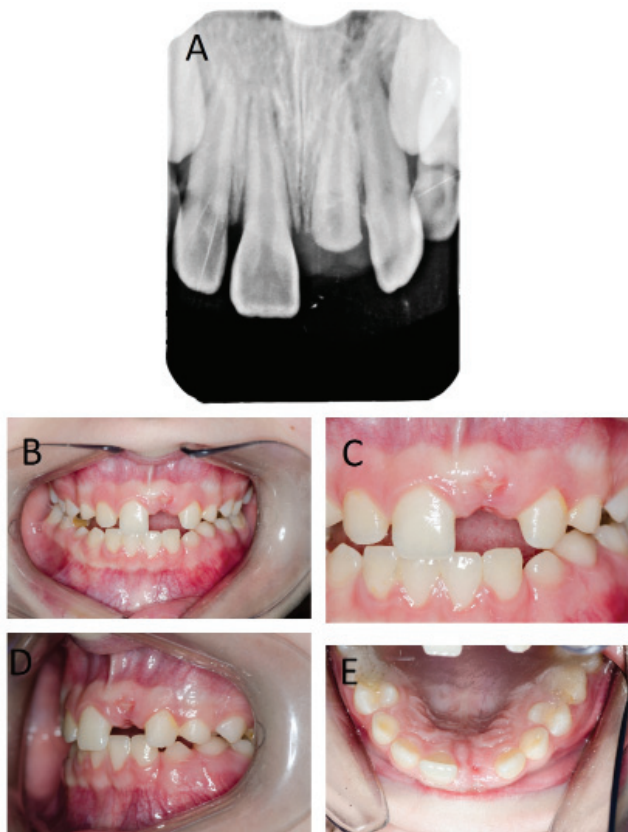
A – dental radiograph of the injured area taken after 7-week period. No inflammatory symptoms could be detected and the process of the closure of the root apex continued. Note the mineralized tissue covering the area of previously exposed pulp. B–E – view of the patient's dentition after 7-weeks from the dental injury. No inflammatory symptoms could be detected clinically
